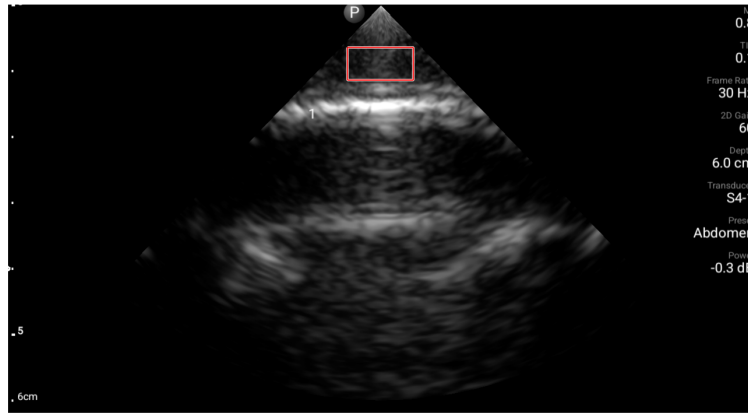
Ultrasound (US) image of a test coupon with the designated Region of Interest (ROI) outlined by red rectangle. The ROI measures 1 cm $\times$ 0.5 cm and was positioned at a depth of 0.65 cm, based on the image's depth scale. It was selected to isolate relevant ultrasound features of the J5 material coupon samples while excluding external artefacts, enabling consistent comparison between coupons for quantitative analysis of material acoustic properties.
